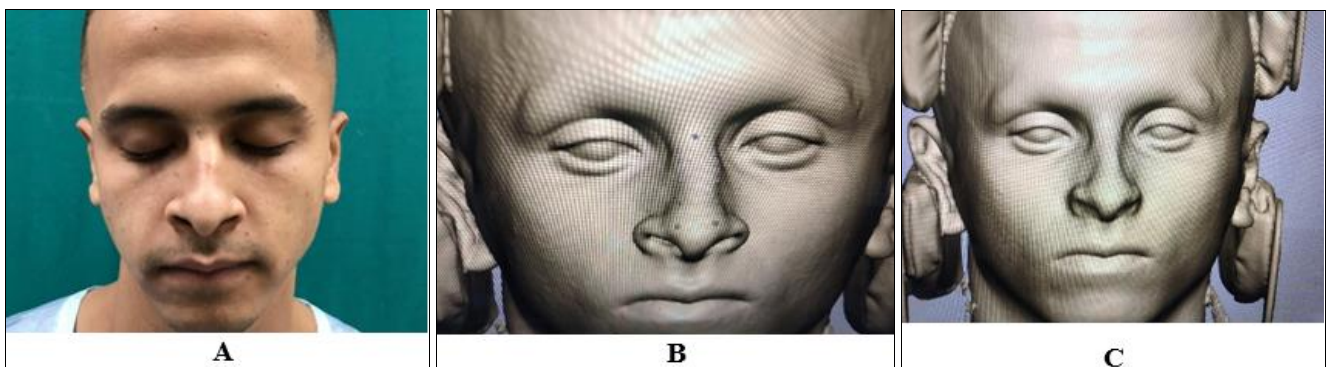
frontal view of case with nasal deviation (a) preoperative frontal view showing twisted nose (b) CT finding (c) virtual planning for correction of twisted nose
